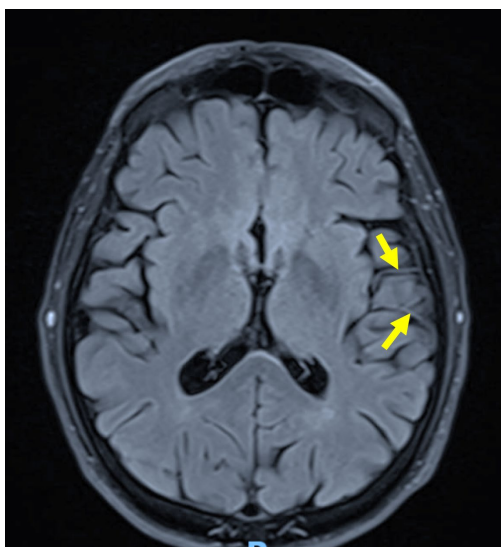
Axial FLAIR MRI demonstrates linear hyperintense signal abnormalities along the cortical and subcortical branches of the left middle cerebral artery (yellow arrows), consistent with FLAIR vascular hyperintensities. These findings are suggestive of slow flow secondary to hypoperfusion in the left MCA territory.
